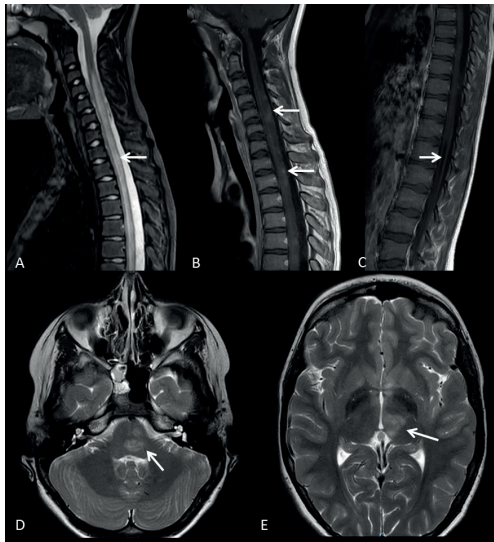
MRI of the spinal cord in a three-year-old boy with Guillain-Barré syndrome.
